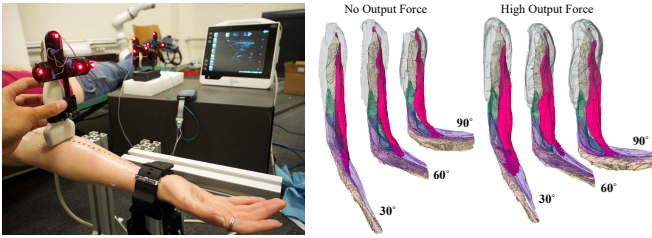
Muscle deformation, as measured via ultrasound, shows promise as a highly localized measure of muscle force. *Left*: Experimental setup enabling the collection of volumetric arm models via ultrasound and motion capture. *Right*: Preliminary volumetric data of the biceps brachii (magenta) and surrounding muscles show measurable deformation due to changes in both elbow angle and load.
